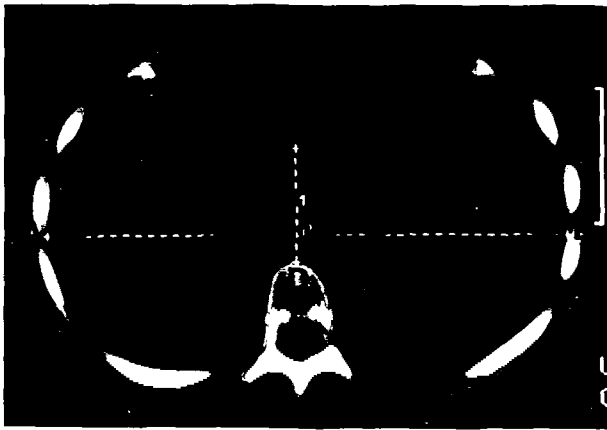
CT scan image with A-B (transverse diameter) and C-D (anterior-posterior diameter) indicated for calculation of pectus index (A-B/C-D).
